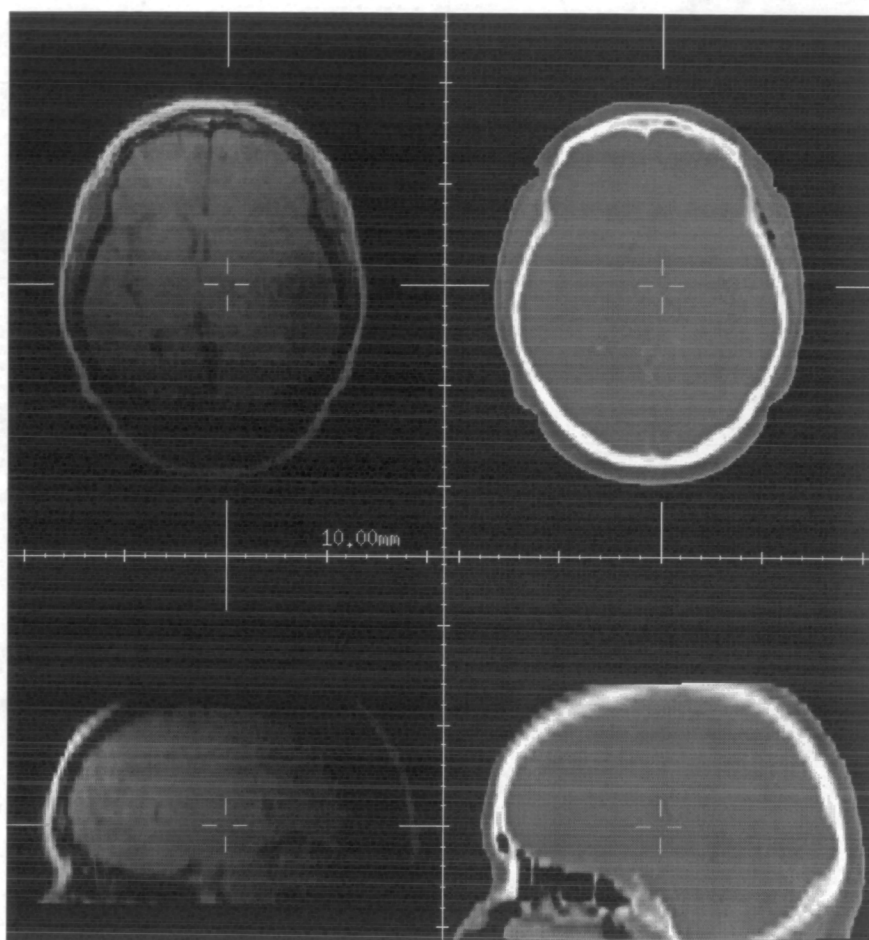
Transaxial and sagittal slices through artificially distorted MR image of the brain and corresponding CT image from the Vanderbilt registration database.
